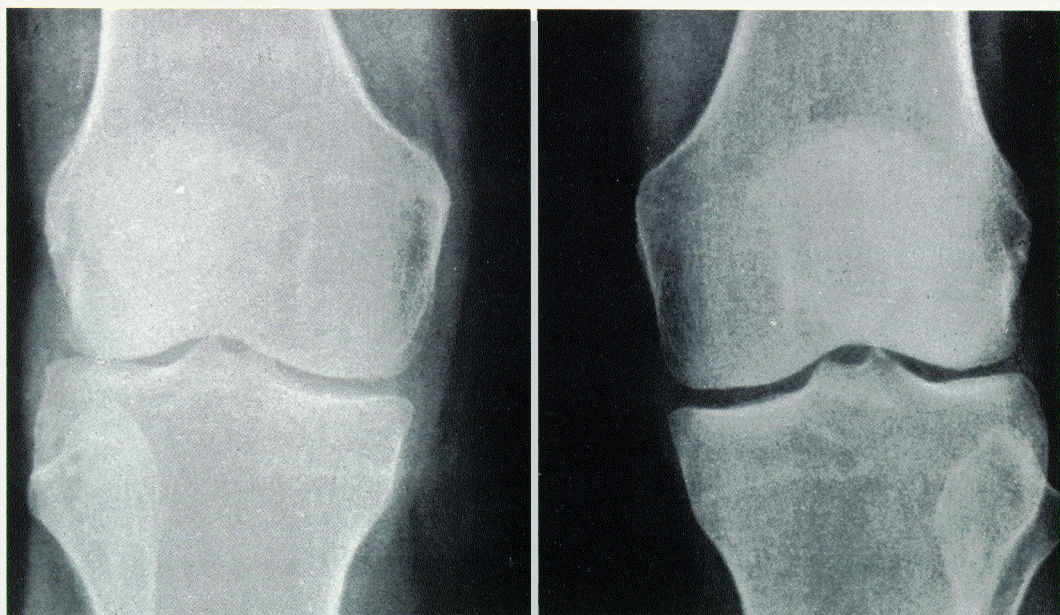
Case 3. X-ray: Only slight asymmetry of the articular space on the right.
